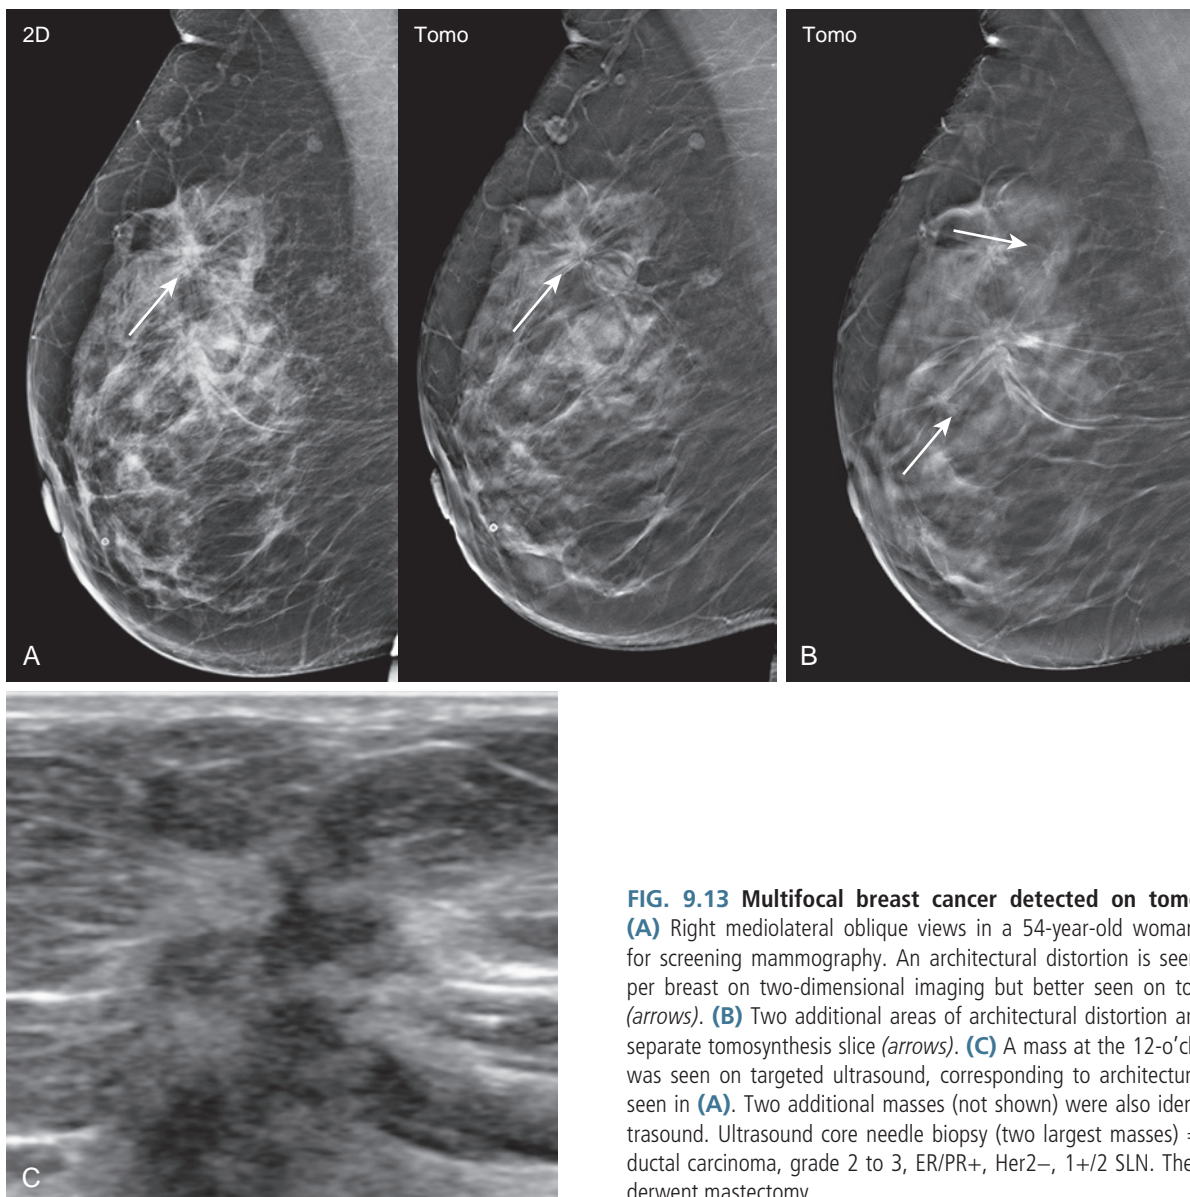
Multifocal breast cancer detected on tomosynthesis. (A) Right mediolateral oblique views in a 54-year-old woman presenting for screening mammography. An architectural distortion is seen in the upper breast on two-dimensional imaging but better seen on tomosynthesis (arrows). (B) Two additional areas of architectural distortion are seen on a separate tomosynthesis slice (arrows). (C) A mass at the 12-o'clock position was seen on targeted ultrasound, corresponding to architectural distortion seen in (A). Two additional masses (not shown) were also identified on ultrasound. Ultrasound core needle biopsy (two largest masses) = infiltrating ductal carcinoma, grade 2 to 3, ER/PR+, Her2-, 1+/2 SLN. The patient underwent mastectomy.
